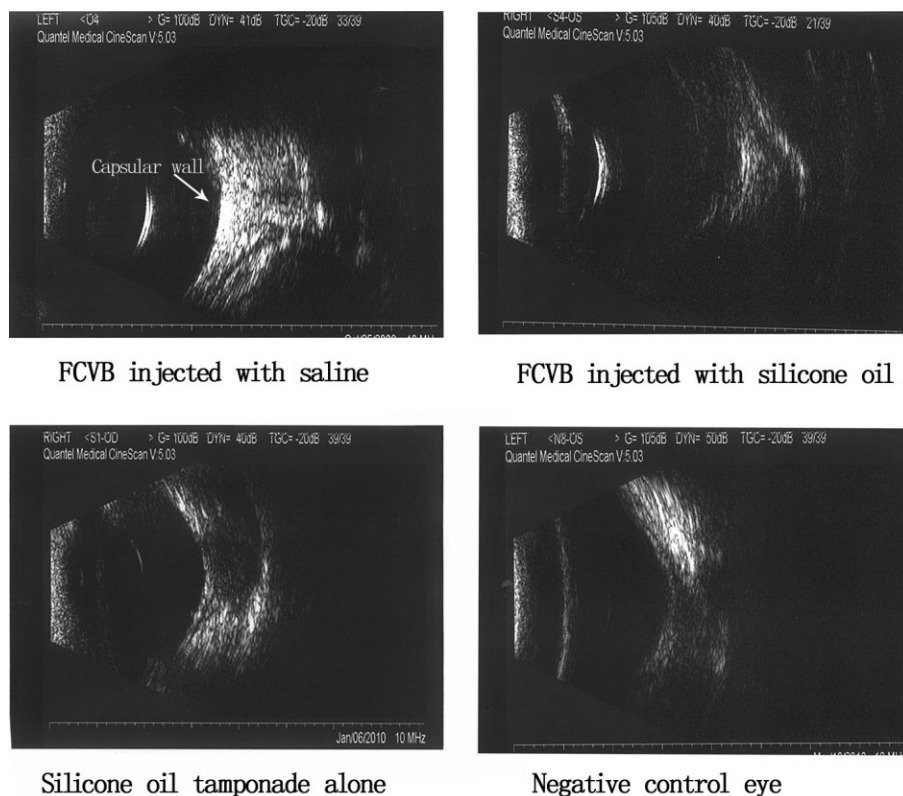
B-scan ultrasonography. B-scan ultrasonography found mild opacity echoes in the vitreous cavity and a smooth curve epiretinal echo enhancement in the rabbit eyes with foldable capsular vitreous bodies (FCVBs) injected with saline. Interference information was evident in the silicone oil in the eyes of the FCVB injected with silicone oil group. Mild opacity echoes in the vitreous cavity were noted in the silicone oil tamponade group.
